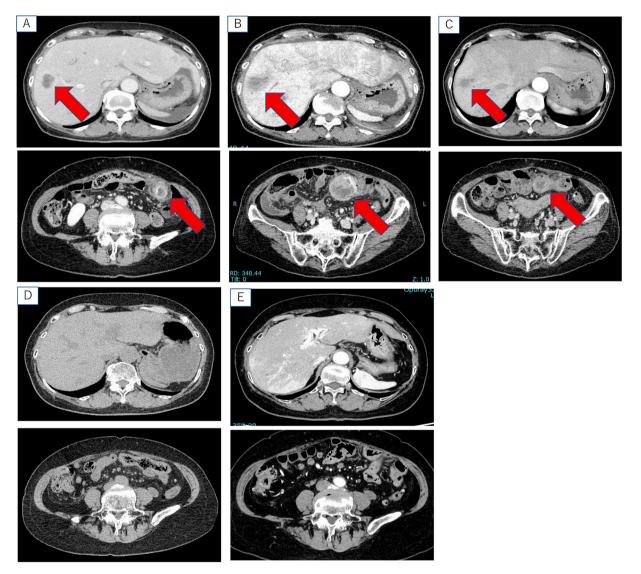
CT shows a decrease in the size of liver metastases and peritoneal dissemination after pembrolizumab administration. (A) Before treatment with pembrolizumab. (B) After two cycles of pembrolizumab. (C) After three cycles of pembrolizumab. (D) After seven cycles of pembrolizumab. (E) Five years after the last pembrolizumab cycle.
